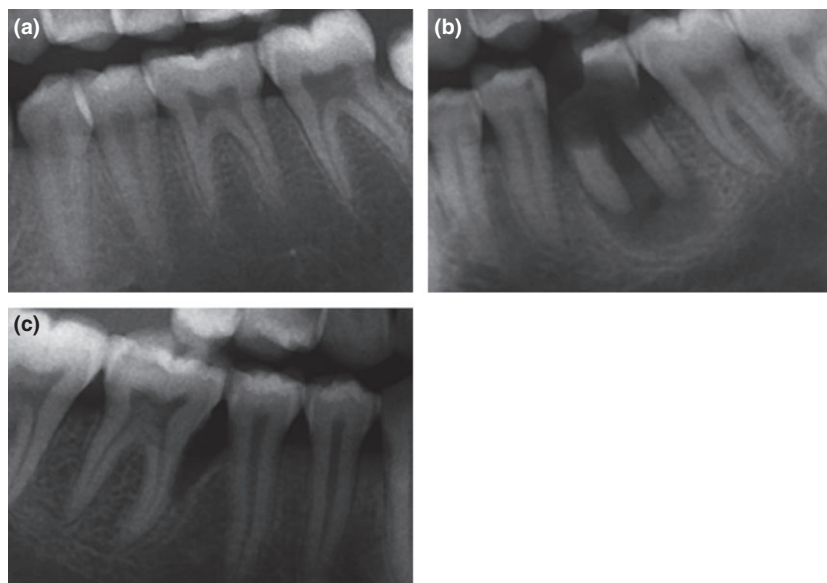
Examples of radiological findings in the study. (a) Healthy dentition and bone structure; (b) Periapical infection, radiolucent lesion surrounding the roots of first lower left molar with deep caries lesion; (c) Periodontitis, deep vertical bony pocket related to first lower right molar.
